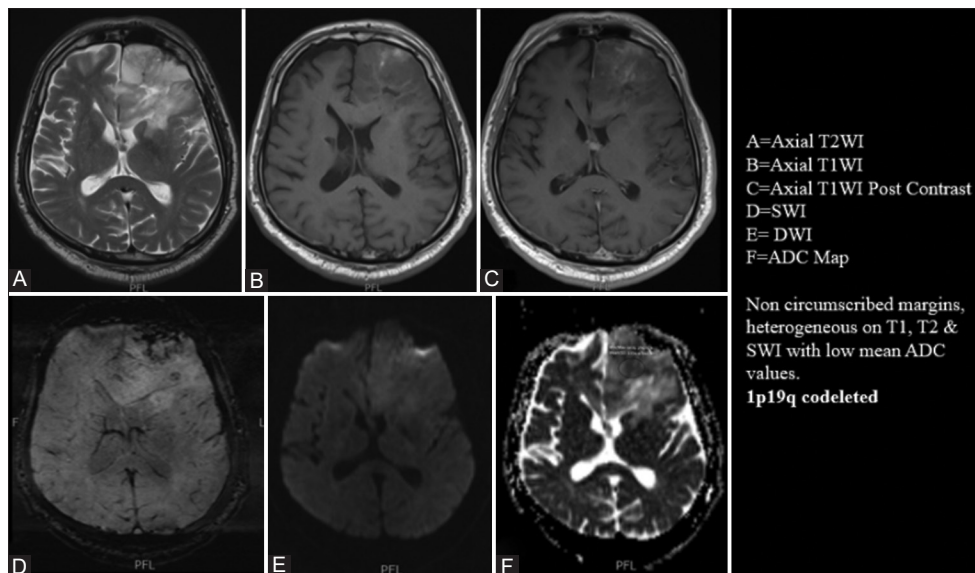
Sample of magnetic resonance imaging in a patient with 1p/19q codeletion
